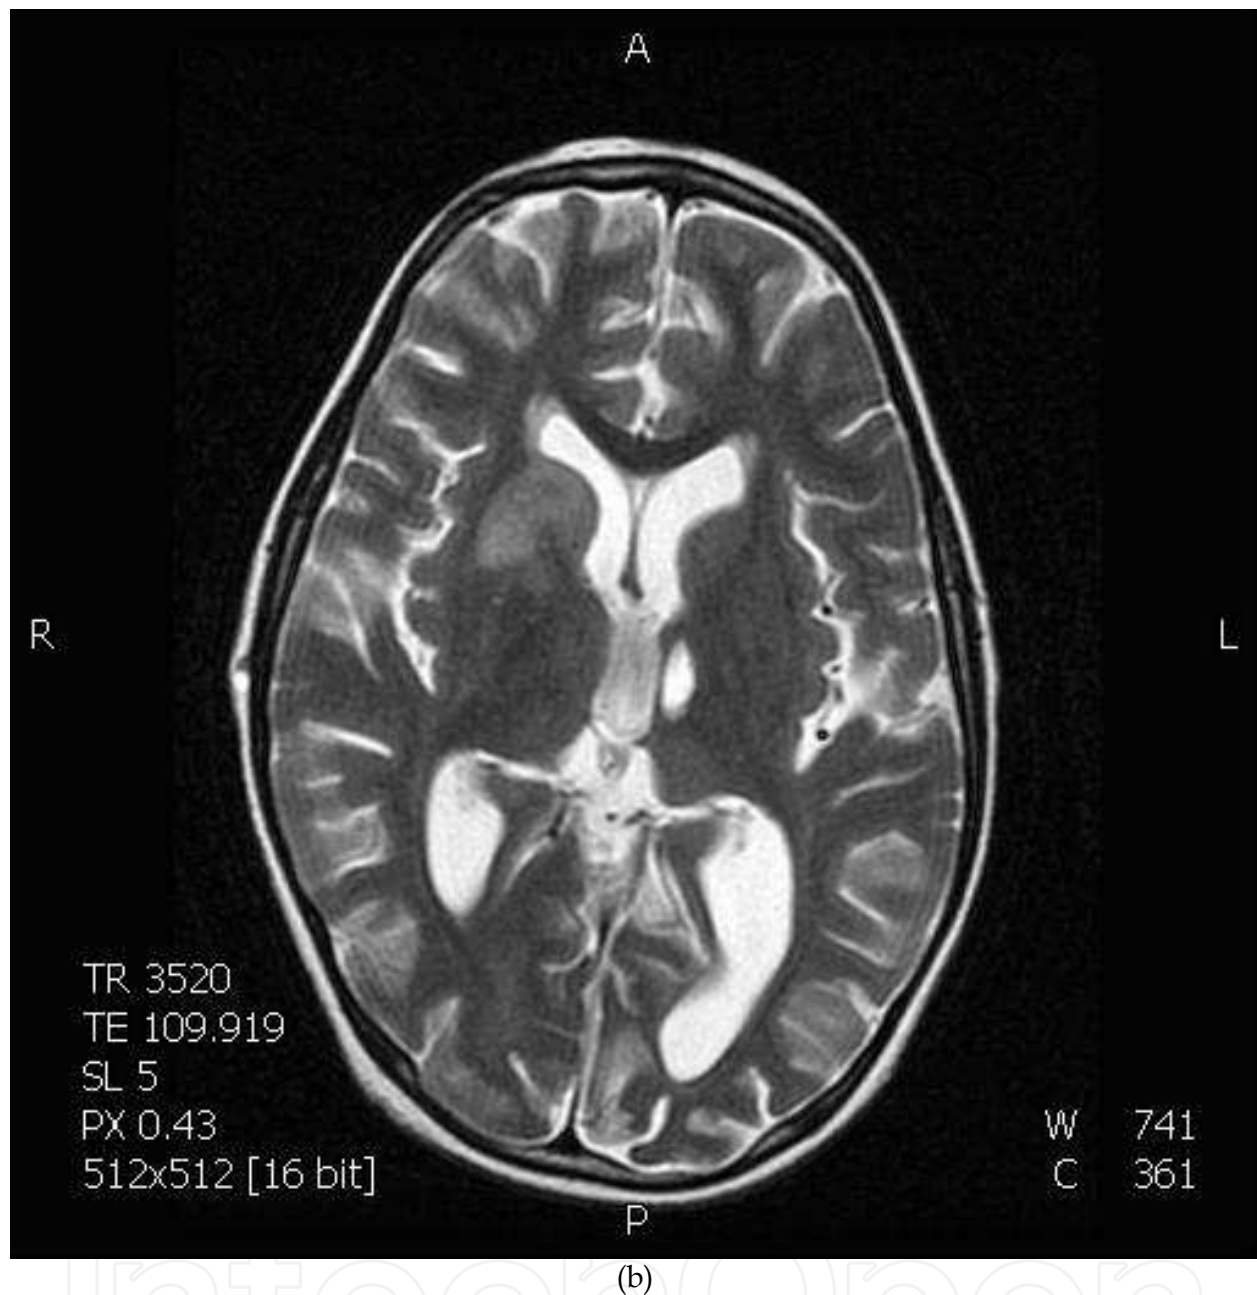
(a, b). Chemotherapy-induced toxicity in a boy diagnosed with acute lymphoblastic leukemia. T2-weighted SE images reveal cerebral involvement as patches with hyperintense areas in periventricular white matter, right occipital cortico-subcortical area and the right corpus striatum. In addition, there is a porencephalic lesion in the left thalamic region.
